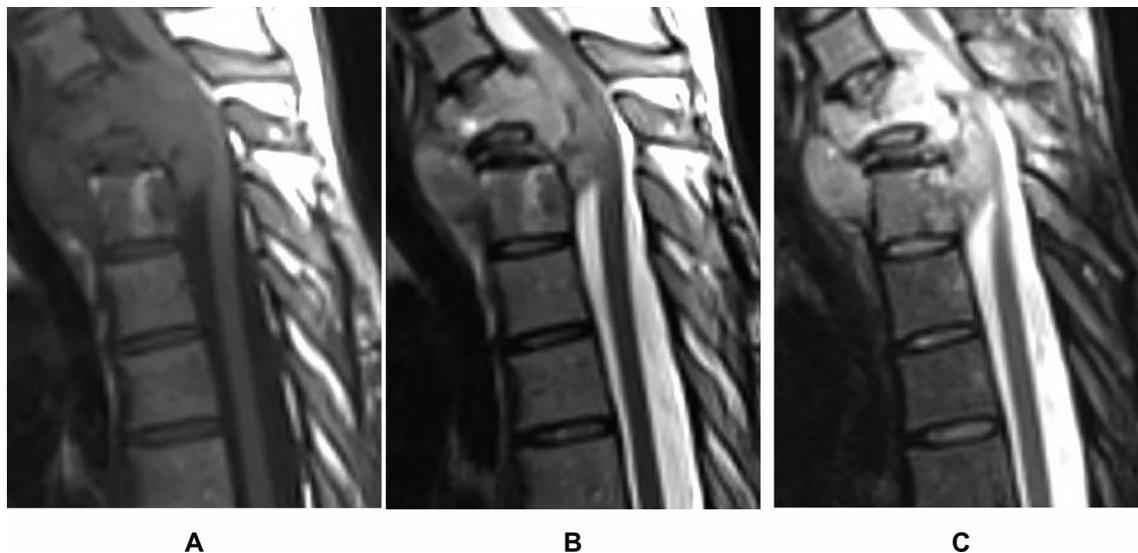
MRI of the cervical-thoracic junction of the patient at admission: A – T1-weighted image; B – T2-weighted image; C – T2-weighted image Fat Suppression
